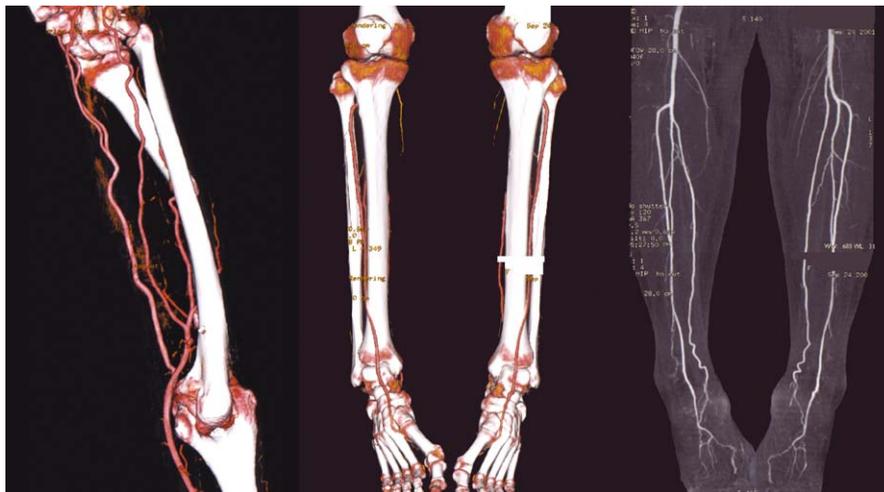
Upper and lower extremity CT angiogram revealing normal vasculature in a patient with a proximal radius defect following to resection for fibrous dysplasia.
